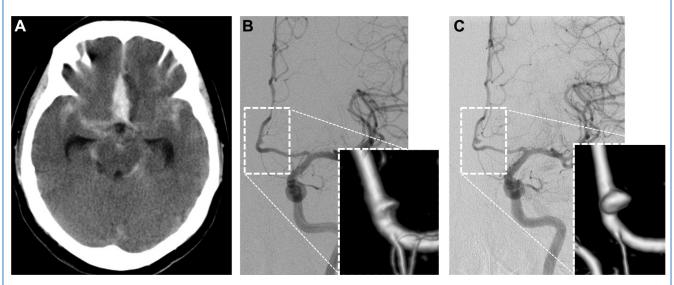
(A) Computed tomography image of a subarachnoid hemorrhage predominantly in the interhemispheric fissure. (B) Left internal carotid angiography on day 0 revealing a 1.5-mm small dissecting aneurysm at the nonbranching site of the left proximal A2 segment. (C) Left internal carotid angiography on day 15 revealing growth of the aneurysm.
